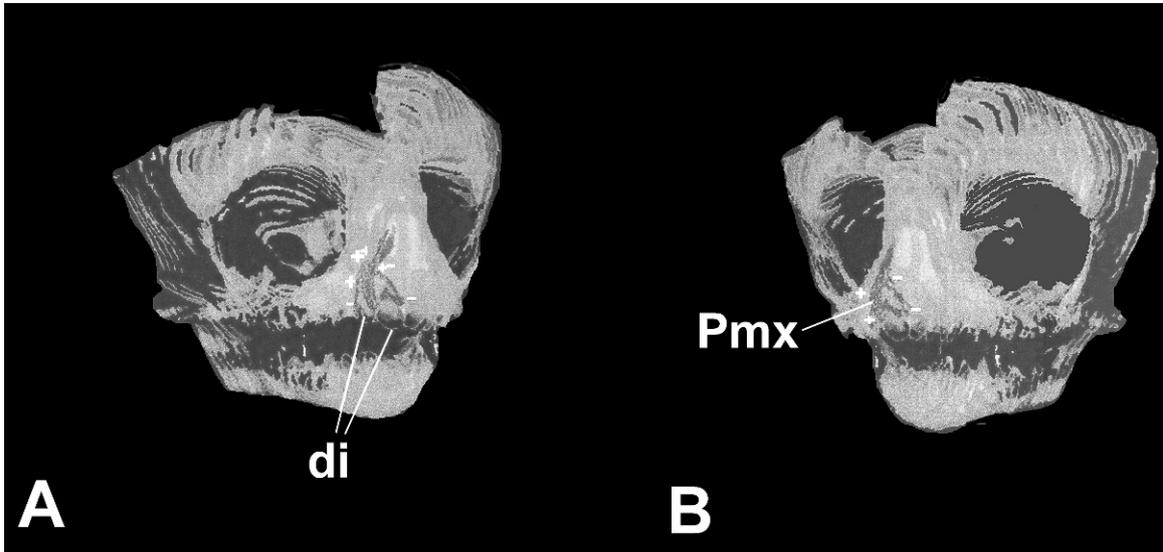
CT scan reconstruction with the Pmx highlighted and the osteoblastic (+) and osteoclastic (-) borders indicated. Anterolateral (A) and anteromedial views (B) of the Pmx of a neonatal *Saguinus geoffroyi* are shown. Note the osteoclastic surfaces at the inferolateral surface (adjacent to the maxillary bone), the interpremaxillary suture, and the medial margin of the nasal process (adjacent to the nasal cavity).
